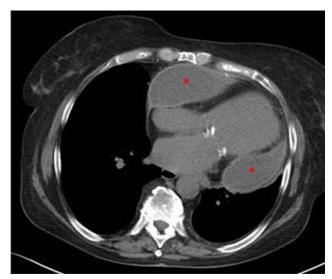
CT of the chest from a patient with rheumatoid arthritis and constriction, demonstrating deformed heart shape with a large pericardial mass (asterisk).
